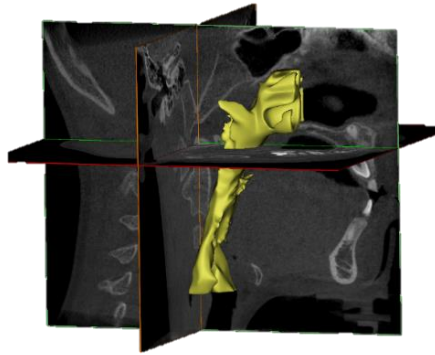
UA segmentation on CBCT images.
